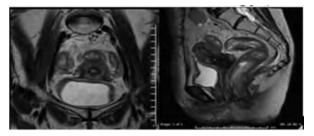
Case number 3, 48 yrs female Ca rectum MRI after immunotherapy (coronal and axial).
